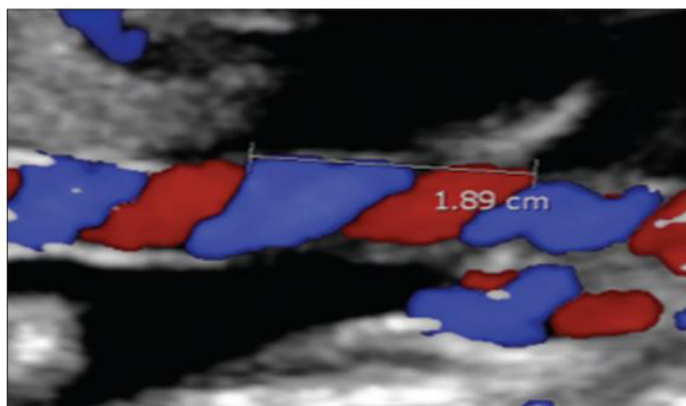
Shows the measurement technique of antenatal umbilical coiling index (a UCI) with doppler shown as above.
